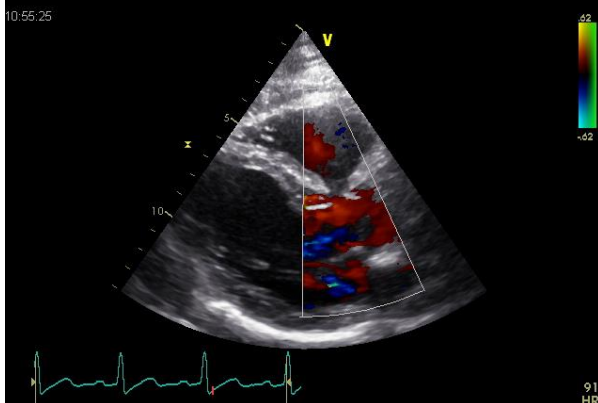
Color Doppler over the mitral valve/aortic valve
